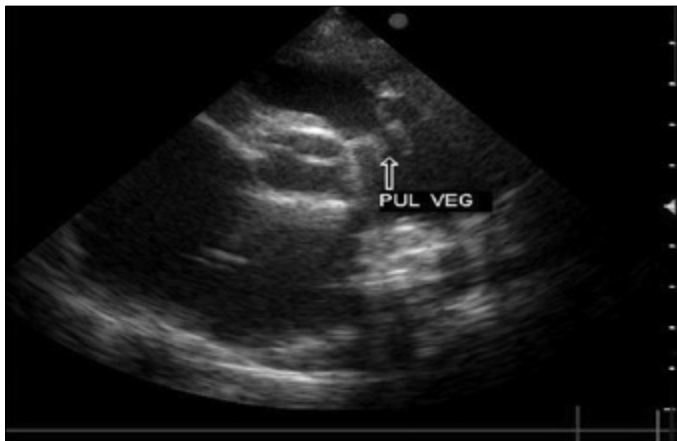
Vegetation on the pulmonary and tricuspid valves in the transthoracic echocardiography (arrow)
